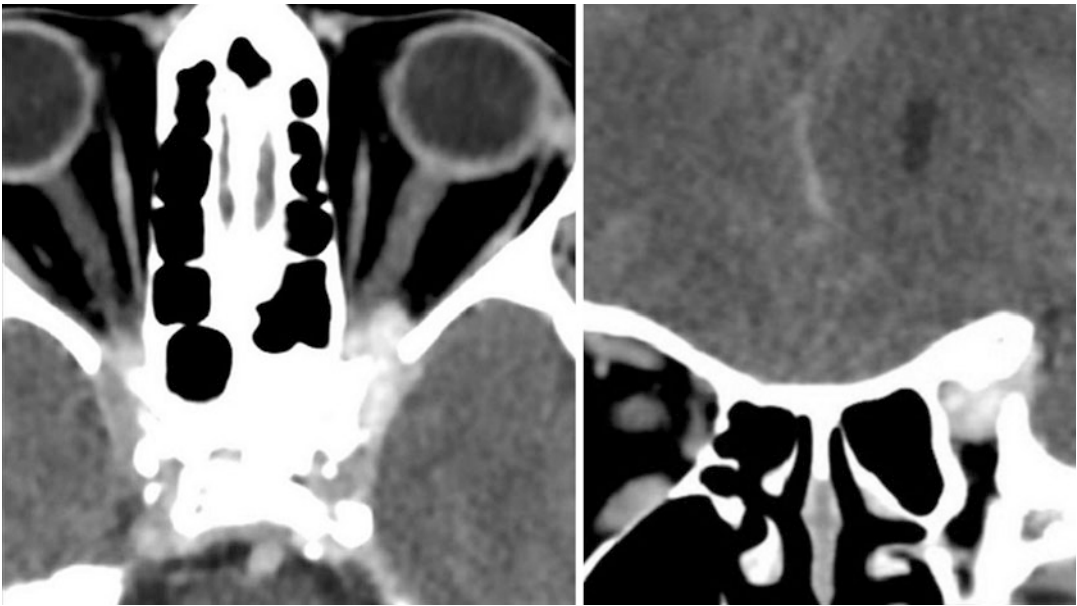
Tolosa-Hunt syndrome in a patient with left-sided ophthalmoparesis and a mild left optic neuropathy. CT scan, axial, and coronal views show an ill-defined mass in the left orbital apex and cavernous sinus
